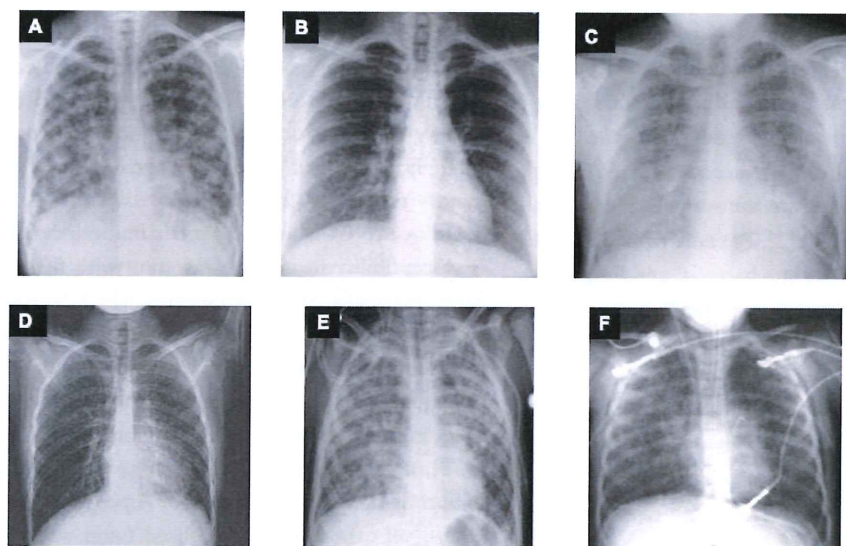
Chest radiographs at presentation for patients 1 (A), 2 (B), 4 (C), 6 (D), 7 (E), and 9 (F). Although the initial film of patient 2 was read as normal, the second films, shown in figure 2, were obtained <24 h later and showed bilateral infiltrates.
